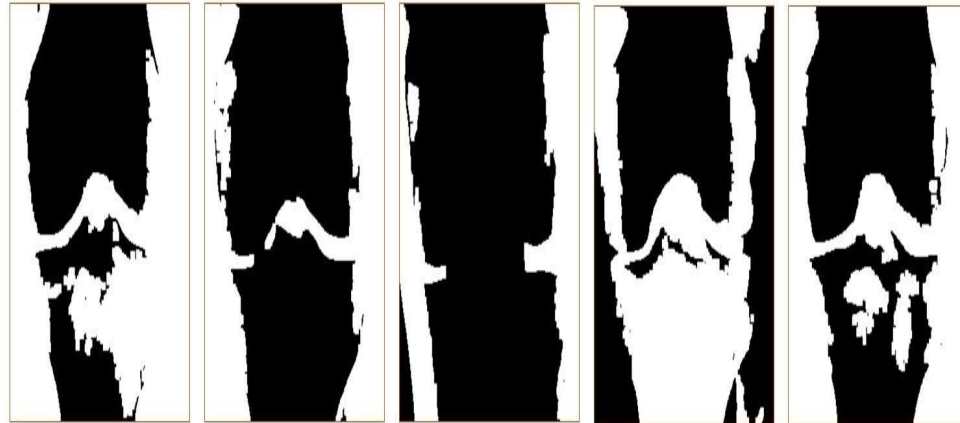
Masked MR images surrounded the bone tissues.
